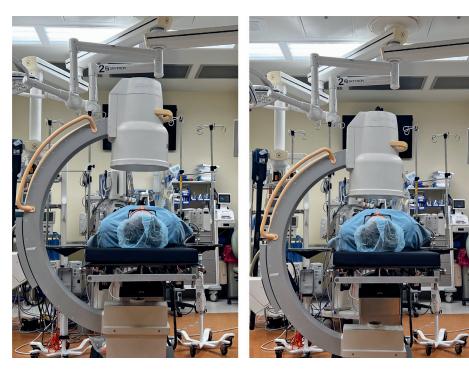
A, The image intensifier is positioned well above the patient, and the x-ray tube is close to the patient. This will result in a higher absorbed dose and a lower quality image. B, The image intensifier is positioned closer to the patient, and the x-ray tube is well below the patient. This will result in a lower absorbed dose and a higher quality image.
